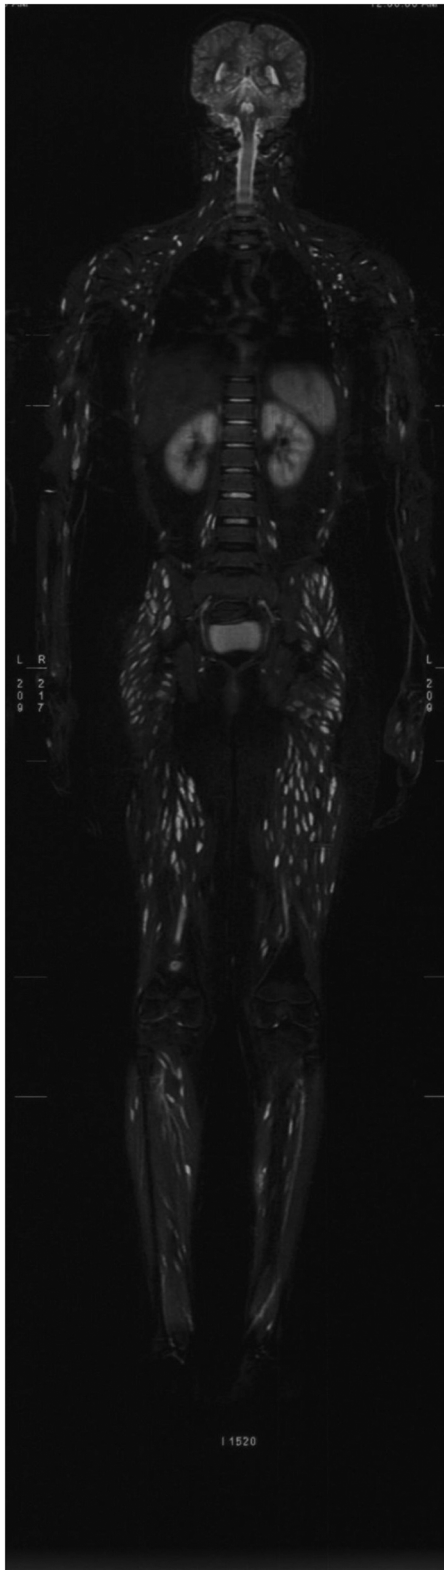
Whole body MRI depicting disseminated cysticercosis. Multiple hyperintense cystic lesions are visualized in the paraspinal muscles, along with involvement of the muscles of the upper and lower limbs. The symmetrical distribution of these lesions indicates widespread dissemination of cysticerci throughout the body consistent with disseminated cysticercosis.
